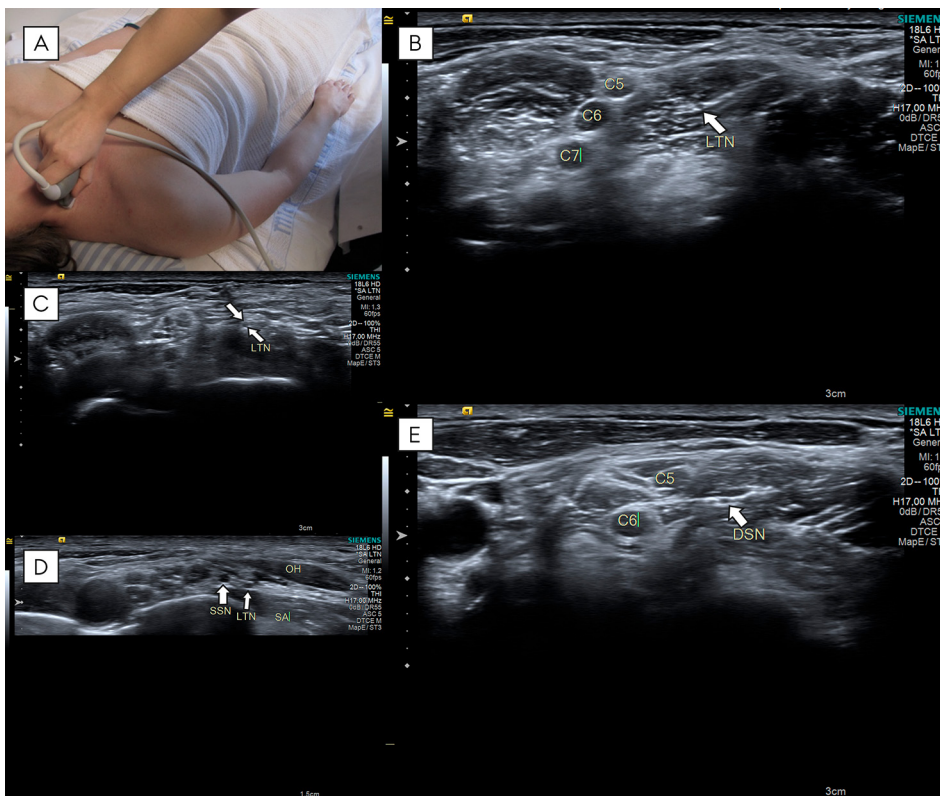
The long thoracic (LTN) and dorsal scapular (DSN). All ultrasound images are of the left side on a healthy subject. A) The probe was placed on the neck on/in front of the sternocleidomastoid muscle. B) LTN1: The LTN (white arrow) in or under the middle scalene muscle at the largest point; lying in a hyperechoic fascial line. C) LTN2: The LTN (white arrows) above the scalene musculature at the largest point. D) LTN3: The LTN above the serratus anterior muscle (SA), under the omohyoid muscle (OH) and in front of the suprascapular nerve (SSN) at the largest point. E) The DSN (white arrow) in the middle scalene muscle at the largest point; lying in a hyperechoic fascial line.
